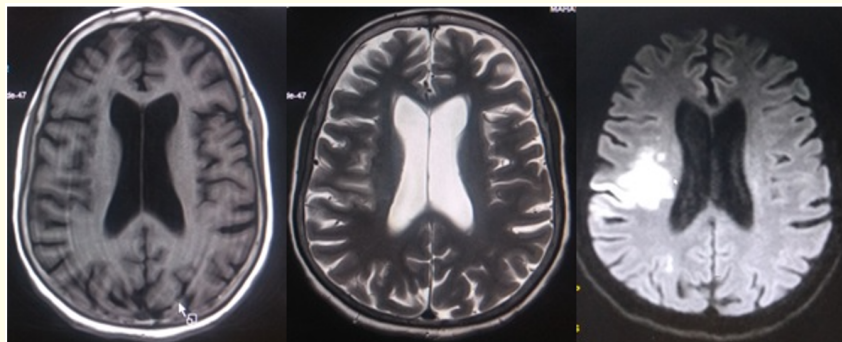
Images of MRI Brain of the patient with T1, T2 and DWI sequences. DWI showing acute infarct in right middle cerebral artery territory.
